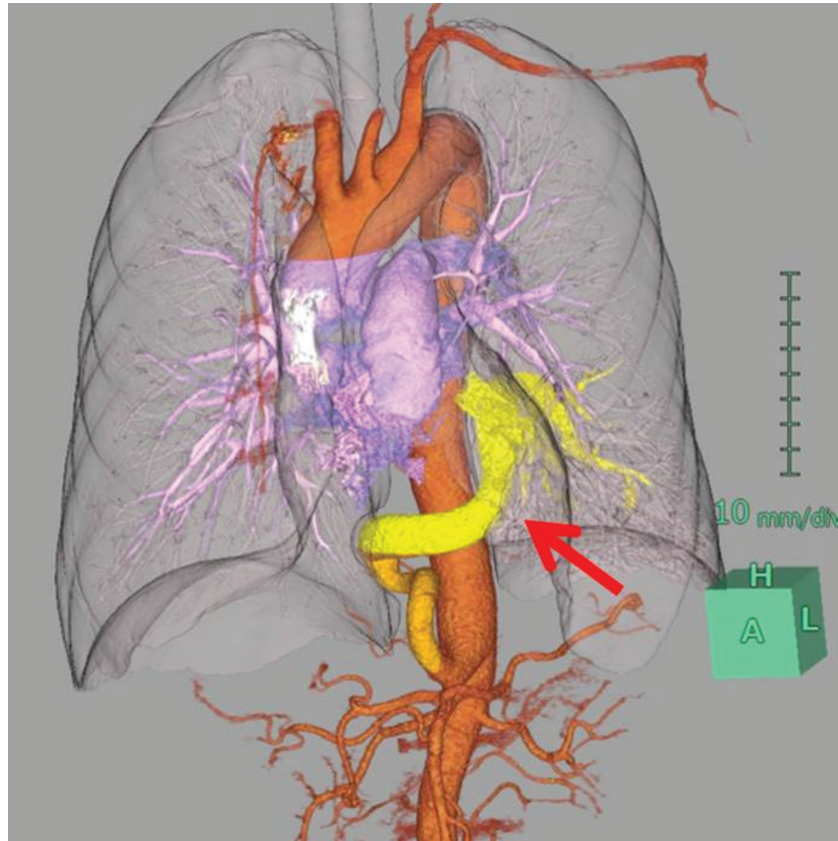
A contrast-enhanced CT shows an aberrant artery originating from the abdominal aorta (arrow).
